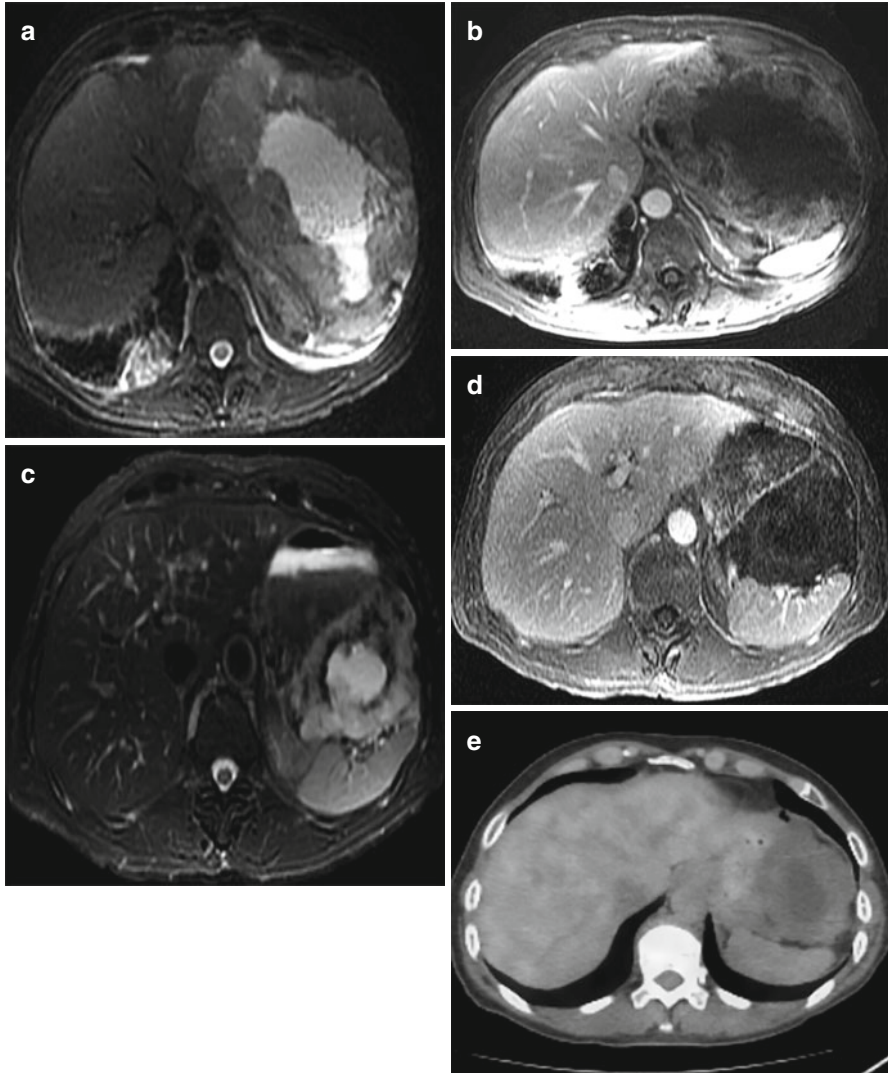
Gastric GIST responding to therapy on MRI. (a, b) The centrally necrotic mass in the left upper quadrant demonstrates central T2 hyperintensity due to necrosis (a) and relative T2 hyperintense rim of solid enhancing component on a contrast-enhanced T1-weighted image (b). (c–e) At 6 months after treatment, the tumor has shrunk, with a decreasing rim of solid tumor on T2-weighted image (c). Note no significant enhancement of the rim on contrast-enhanced T-weighted image (d) and no significant FDG uptake on PET (e).
